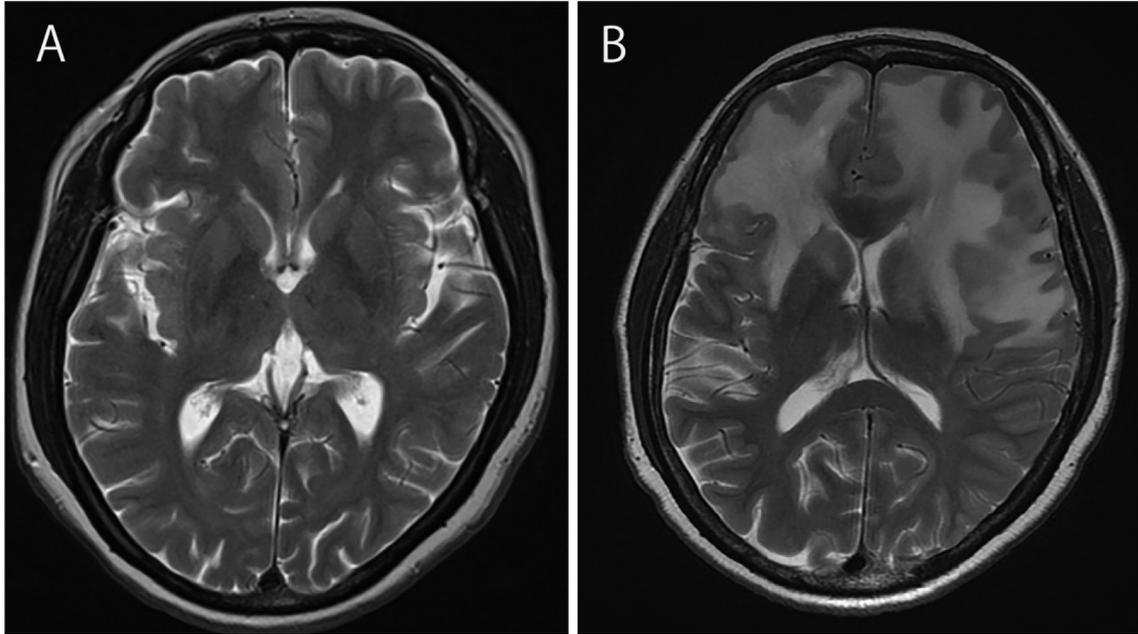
A representative case with primary vitreoretinal lymphoma. A: Magnetic resonance imaging detected no tumor lesions upon initial presentation. B: Marked white-matter progression was detected several years after treatment.
